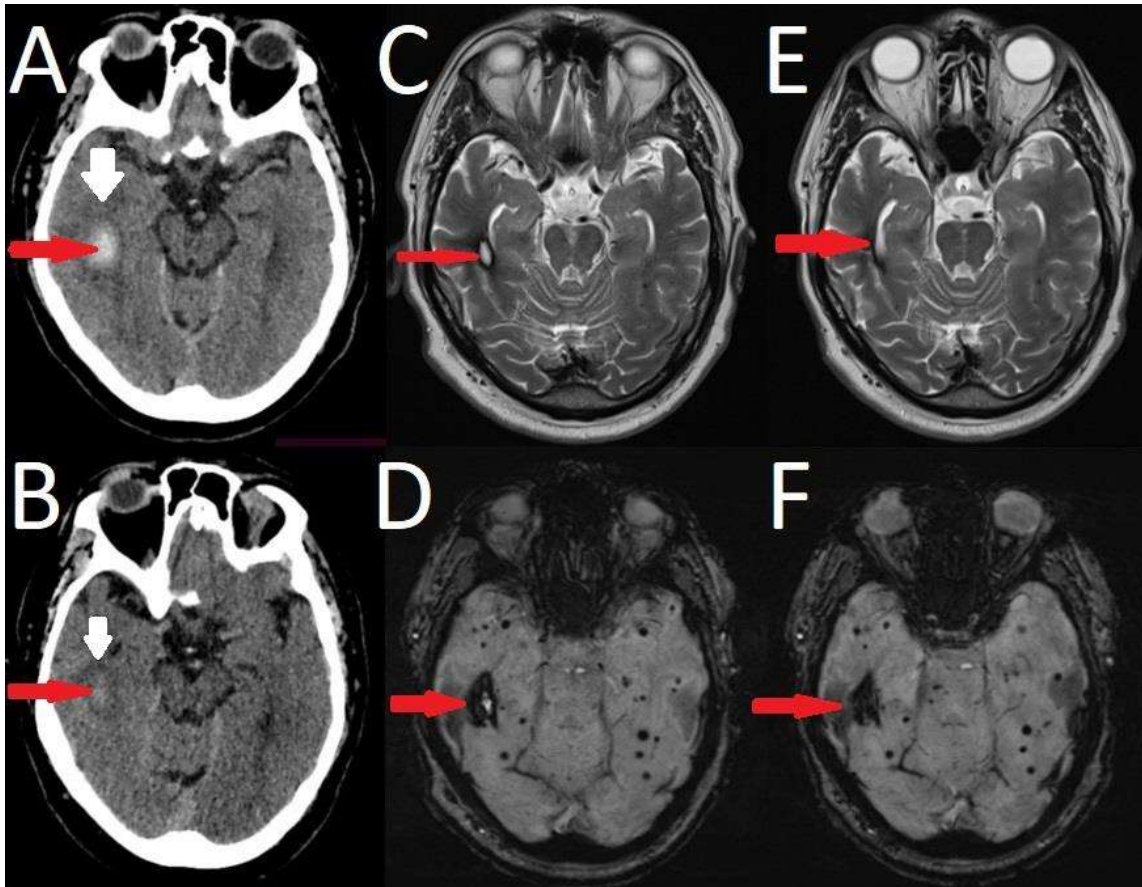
Image A. Acute right temporal ICH (red arrow) with peripheral edema (white arrow); Image B. Partial resolution of the hematoma and peripheral edema at 7 days; Images C and D. MRI exam 2 months after the onset of symptoms. The T2-weighted sequence (image C, red arrow) shows a partially resolved hematoma while the susceptibility-weighted sequence (image D, red arrow) shows a globulous deposit of hemosiderin. Images E and F. Another MRI exam 3 months after the onset of symptoms. T2-weighted sequence (image E, red arrow) shows complete resorption of the hematoma, while the SWI sequence (image F, red arrow) has minimal changes. Besides the right temporal hematoma, the patient had lots of SWI-hypointense lesions with lobar and non-lobar distribution (Images D and F)
